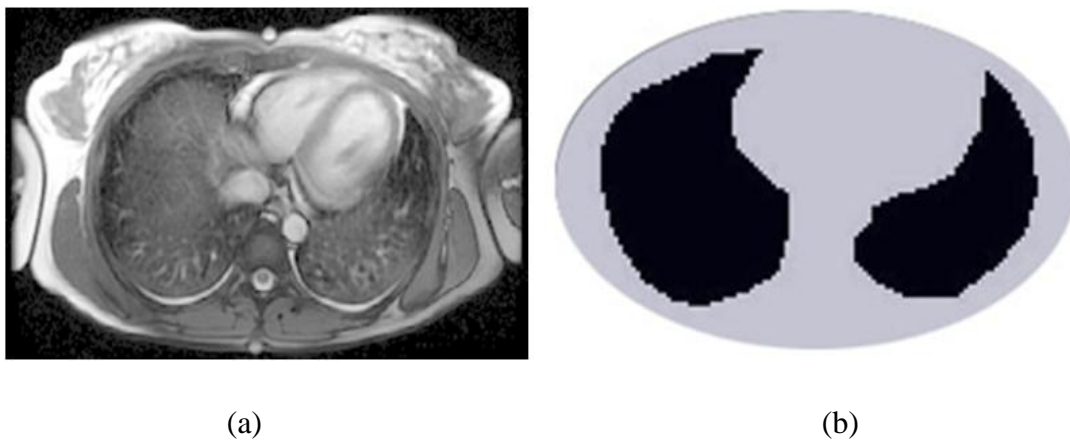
(a) MR images taken at 5cm above xyphoid. (b) Extracted exact lung region and approximate ellipse body shape.
